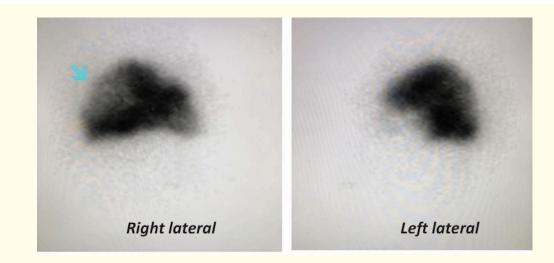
Imagine of perfusion scintigraphy: lateral image: abnormal tracing, cold spot suggestive of pulmonary embolism on the apical segment of the right inferior pulmonary lobe.
